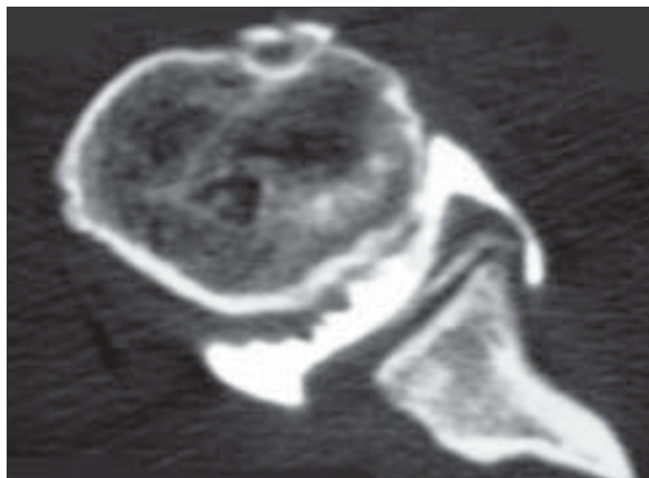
Arthro-CT scan. Transverse view showing injected contrast material extending into a tear of the anteroinferior labrum
